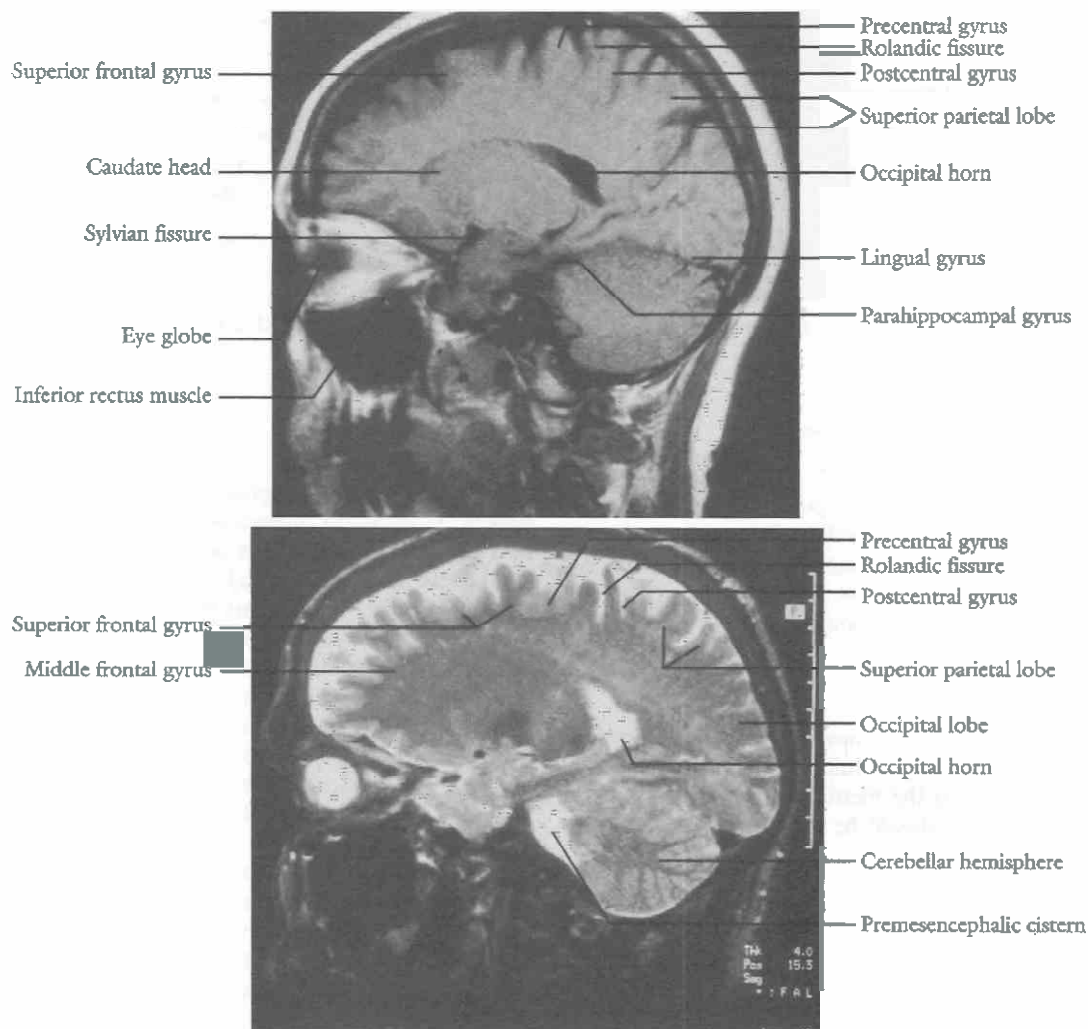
Top*, Sagittal T1 MRI scan through the body of the lateral ventricle. *Bottom*, Sagittal T2 MRI scan through the body of the lateral ventricle.
